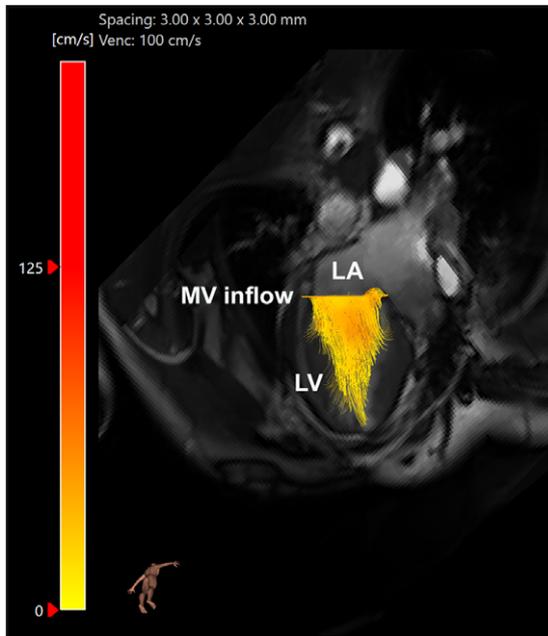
4D flow MRI mitral inflow during max E-wave inflow in a patient with tricuspid atresia and Fontan circulation. LV = left ventricle; LA = left atrium; MV = mitral valve.
